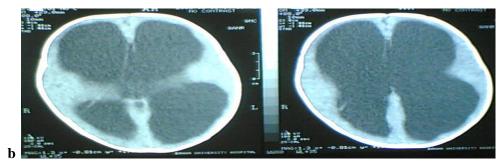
a,b: CT brain images in failed ETV case; a) Pre op, b) Post op 2 months with progressive decrease thickness of brain mantle.
